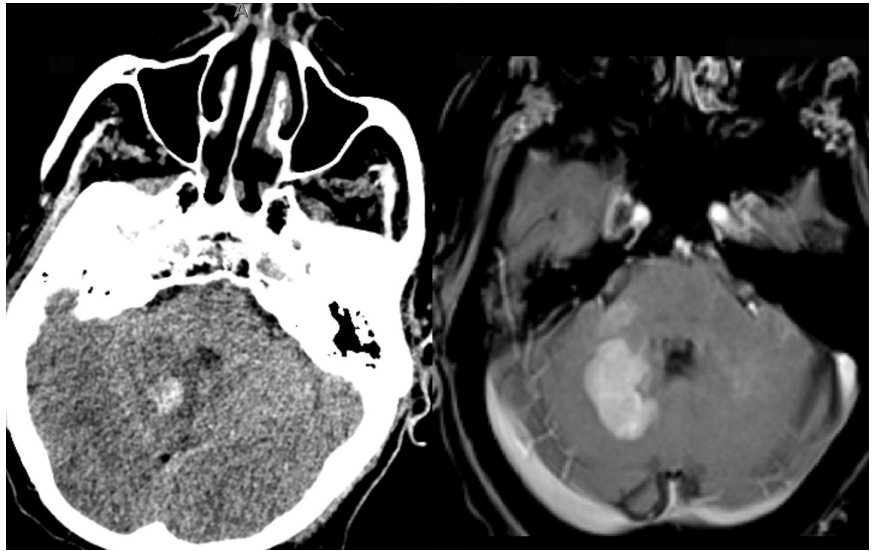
Lymphoma. A 75-y/o with dizziness and slurred speech. Brain biopsy was c/w diffuse large B-cell lymphoma, FISH negative for BCL2, BCL6, and MYC rearrangements. CT chest/abdomen/pelvis revealed no evidence of systemic lymphoma. CT of the head (left) shows hyperattenuation within the right cerebellar peduncle, and homogenous contrast enhancement (right) on the cranial MRI.
